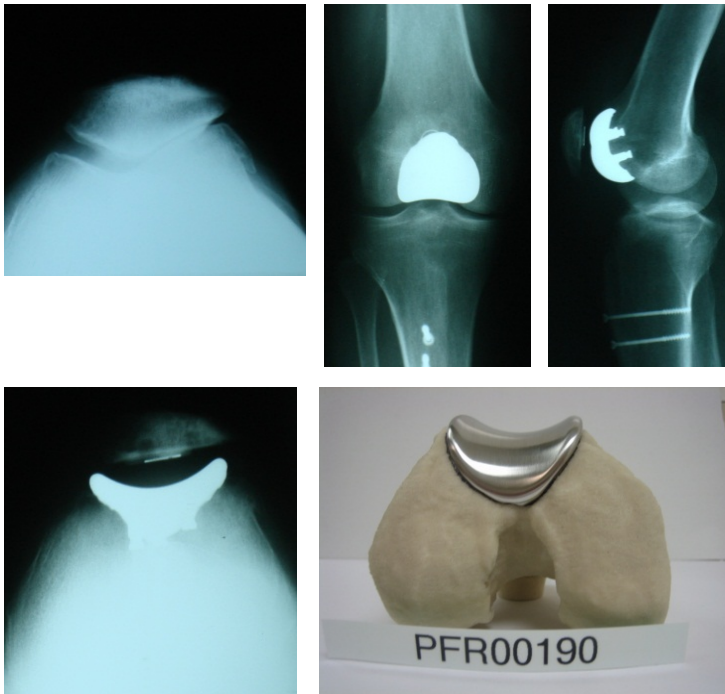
A 49 year old male with isolated end-stage patellofemoral arthritis, without evidence of trochlear dysplasia as seen in pre-operative Merchant view (top-left), treated with a patient-matched patellofemoral prosthesis and all-polyethylene patella button. Post-operative anterior-posterior (top-middle), lateral (top-right), and Merchant (bottom-left) views demonstrate proper orientation of patellofemoral prosthesis. Placement, fit, and alignment of the patient-specific trochlear implant was confirmed by the manufacturer using the patient-specific CT bone model prior to final polishing (bottom-right).
